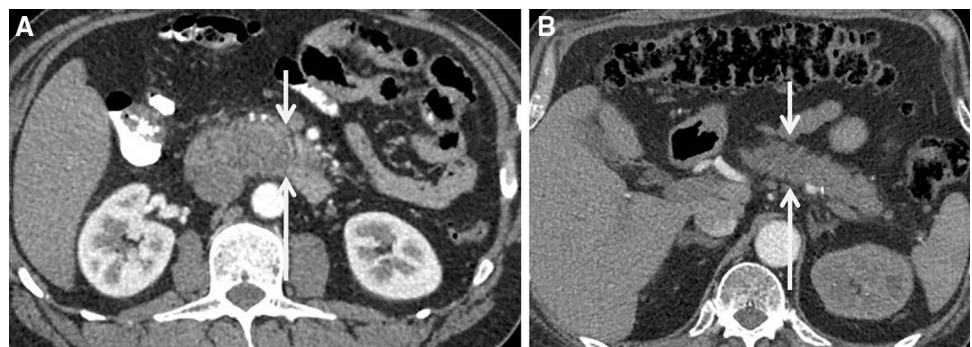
Distribution of findings: axial CT scan showing distribution of findings more than 70 % of pancreas
